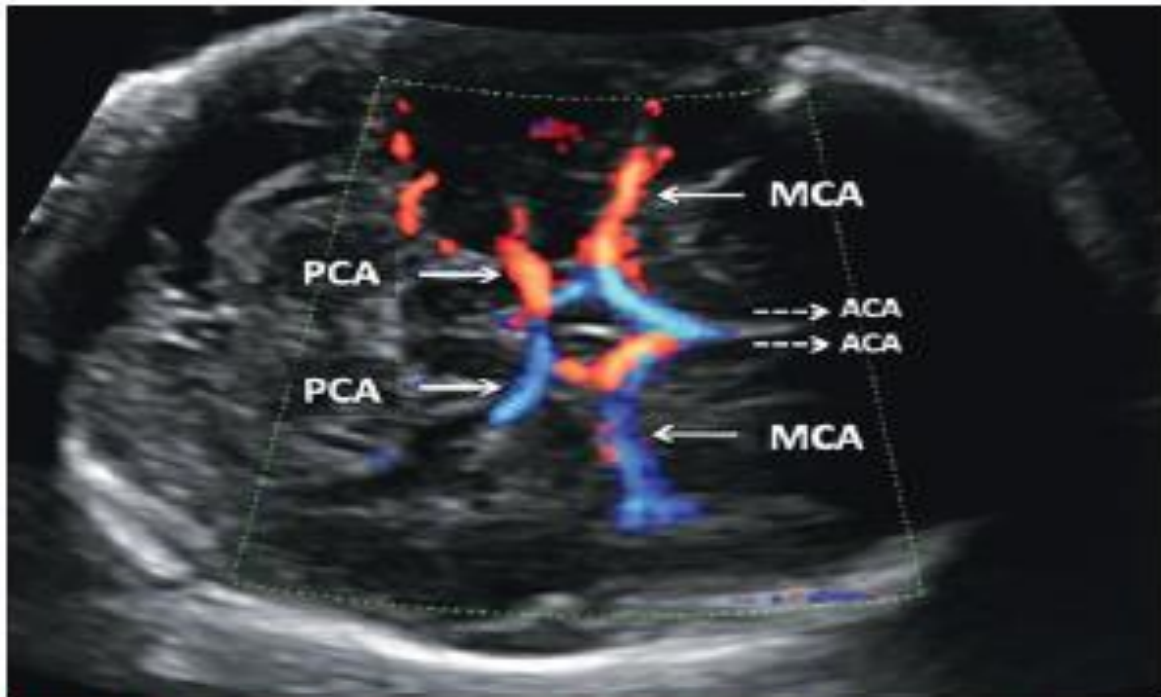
Circle of Willis – color Doppler image. anterior cerebral artery (ACA); middle cerebral artery (MCA); posterior cerebral artery (PCP)
